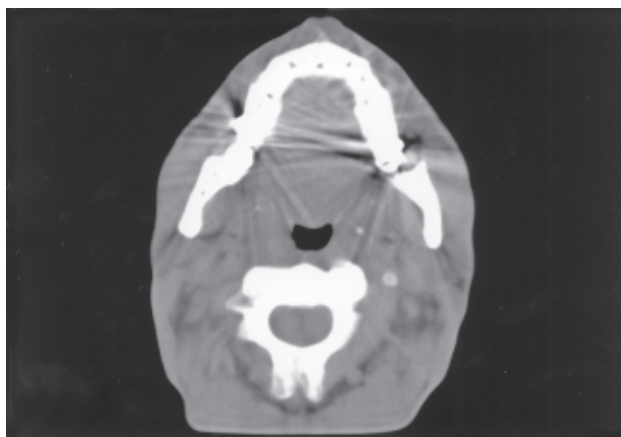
Axial computed tomography scan through the face at the level of the mandible demonstrates minimal facial subcutaneous fat.
